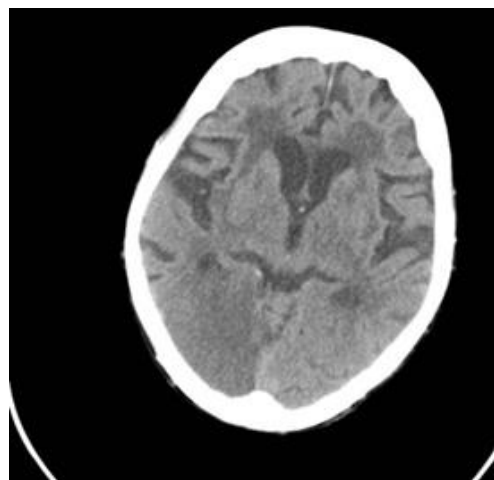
Computed Tomography of the brain of the studied patient with ischemic stroke in the right posterior cerebral artery (PCA) territory.
